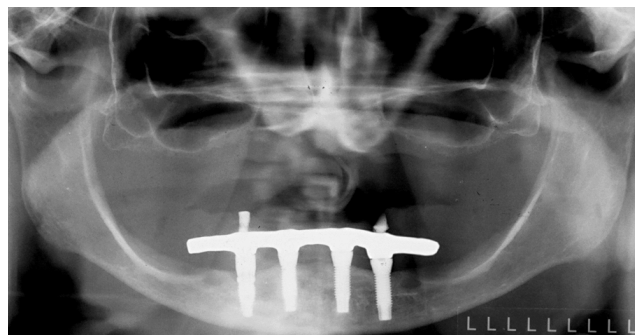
A panoramic radiograph showing edentulism. The radiopaque images reveal the presence of four dental implants in the anterior-inferior region.
